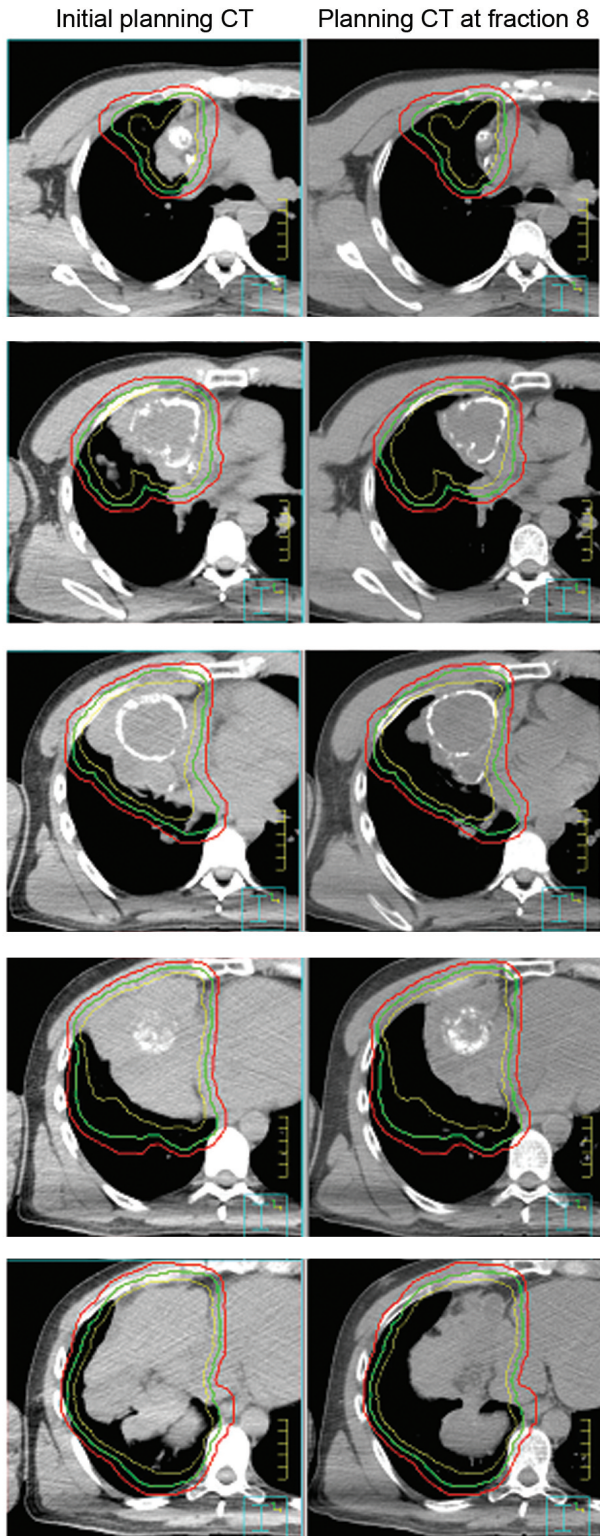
Planning computed tomography (CT). Initial (left column) and new (right column) 4DCT average intensity projection planning scans with initial internal target volume (ITV), initial clinical target volume (CTV), and initial planning target volume (PTV) drawn on both sets of scans for comparison.
